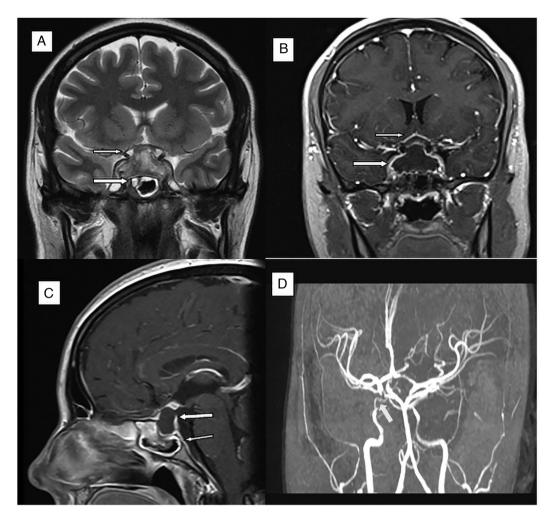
Magnetic resonance imaging (MRI) images of our case. (A) T2-weighted coronal image showing a cystic pituitary tumor (thick arrow) compressing the optic chiasm (thin arrow). (B) Post-contrast T2 showing a cystic pituitary mass (thick arrow) compressing the optic chiasm (thin arrow). (C) Sagittal-cystic mass (thick arrow), and thickened muscosa of the sphenoidal sinus (thin arrow). (D) Bilateral reduction of the intracavernous diameter of the carotidian artery, more prominent on the right side (arrow).
